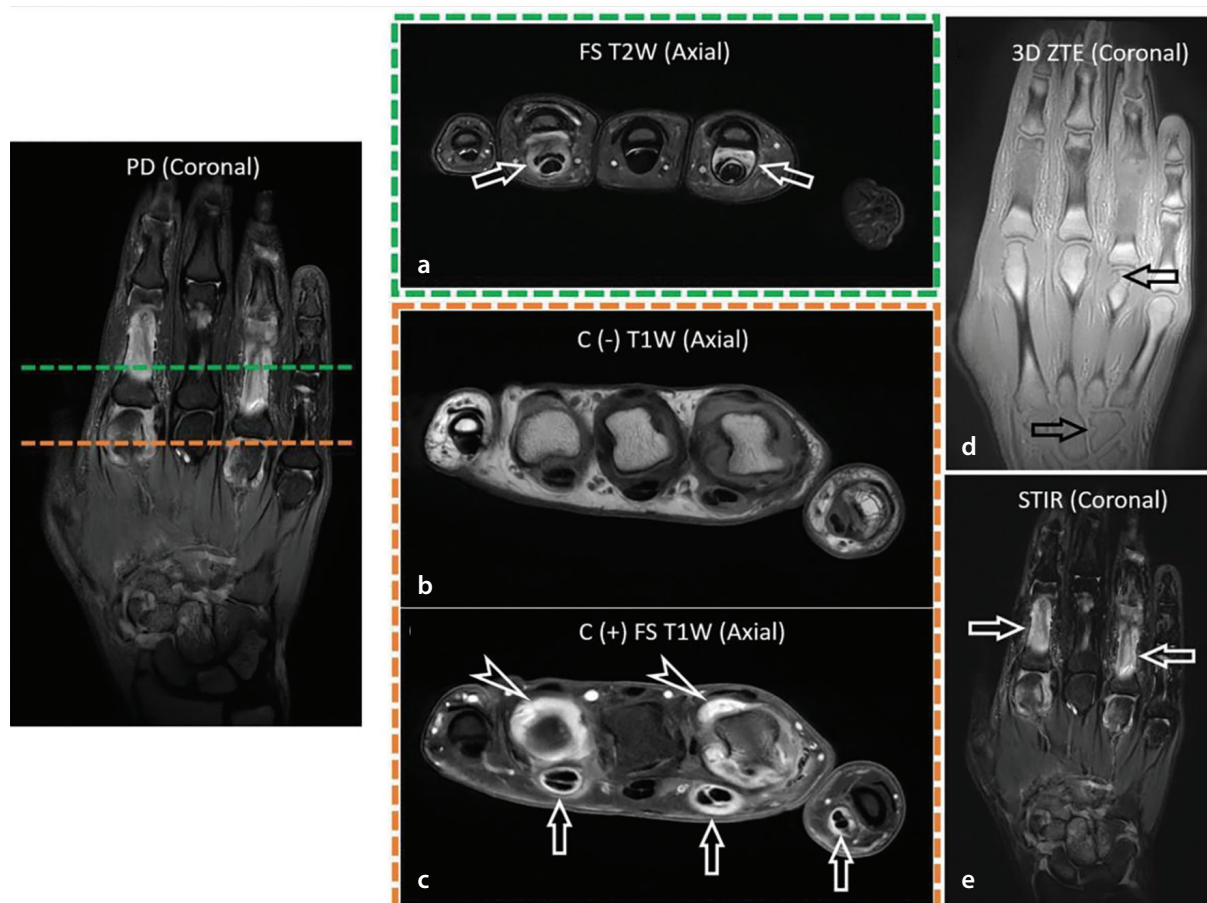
A patient with predominantly synovial inflammation. A 22-year-old female patient had been experiencing diffuse pain and swelling in her hands, more pronounced in the left hand, for the past 6 months. Magnetic resonance imaging (MRI) showed flexor tenosynovitis in the first, second, and fourth fingers (a, c, and e, arrows). There was also prominent synovitis and effusion in the metacarpophalangeal (MCP) joints that are easily seen as enlargement of joint spaces on pre-contrast T1W image (b) with intense contrast enhancement on post-contrast images (c, arrowheads). Additionally, synovitis was accompanied by erosions in the wrist and MCP heads, most notably on the radial side of the fourth metacarpal [(d) arrows]. These MRI findings were consistent with an inflammatory arthritis characterized by intense synovial inflammation, leading to a diagnosis of seropositive rheumatoid arthritis. 3D, three dimensional; ZTE, zero time to echo; C-, contrast enhanced; C-, contrast non-enhanced; FS, fat saturated; T1W, T1-weighted; T2W, T2-weighted; PD, proton density-weighted.
